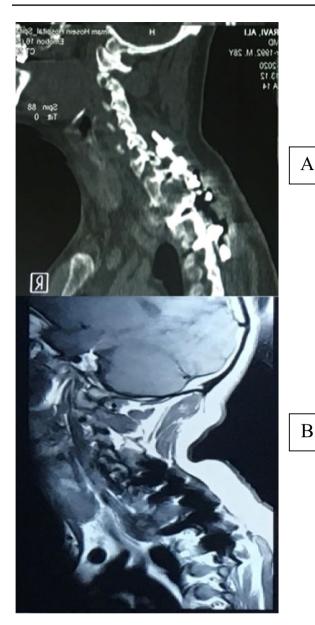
Sagittal reconstructed CT scan (A); T2-weighted MRI image (B); 6 months after operation demonstrating no growth in tumor remnant
